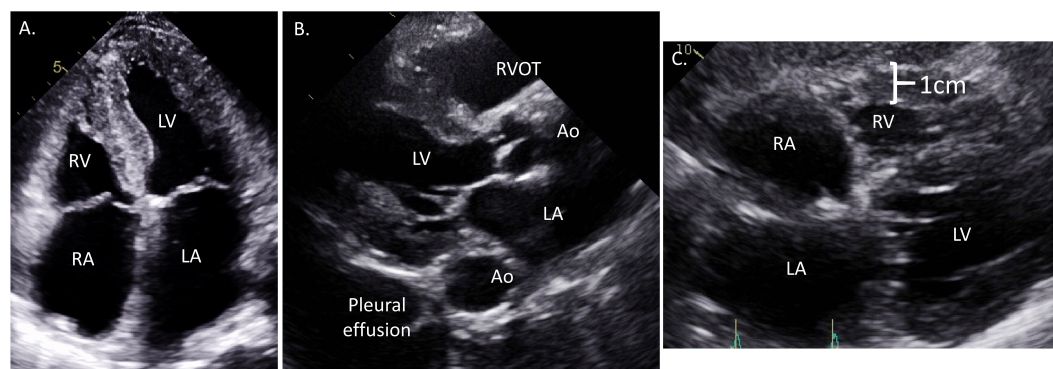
Representative echocardiographic images from a patient with cardiac amyloidosis. (A) Apical 4-chamber view showing moderate concentric left ventricular hypertrophy with more prominent proximal septal hypertrophy, significant bi-atrial enlargement, and diffusely thickened atrioventricular valves. (B) Parasternal long axis view showing large pleural effusion, moderate concentric hypertrophy, small left ventricular end diastolic diameter (LVEDD), and right ventricle outflow track dilation. (C) Subcostal view demonstrating significant right ventricular hypertrophy, biatrial enlargement, and interatrial septal thickening.
